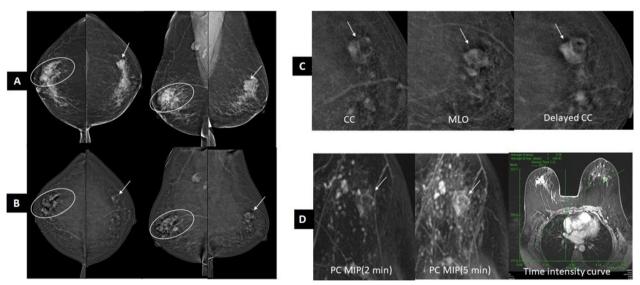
Images of a 55-year-old lady with a right breast lump: A low energy images of both breasts in craniocaudal (CC) and mediolateral oblique (MLO) projections show an irregular mass with indistinct margins in outer central quadrant of right breast (marked by white circles) and an irregular mass with circumscribed margins in left breast (marked by arrows). B Postcontrast recombined images of both breasts show heterogeneous enhancement of the masses in both breasts. Right breast C postcontrast recombined images of left breast lesion (marked by arrows) show progressive increase in density from CC (2 min) to MLO (4 min) to delayed (8 min) views suggestive of type I kinetics. D Postcontrast subtraction maximum intensity projection (MIP) MR images at 2 min and 5 min show progressive increase in density of mass (marked by white arrows) at 5 min consistent with type I kinetics. Time intensity curve confirms the same. Biopsy from the right breast mass was invasive ductal carcinoma, and the left breast mass was fibroadenoma
